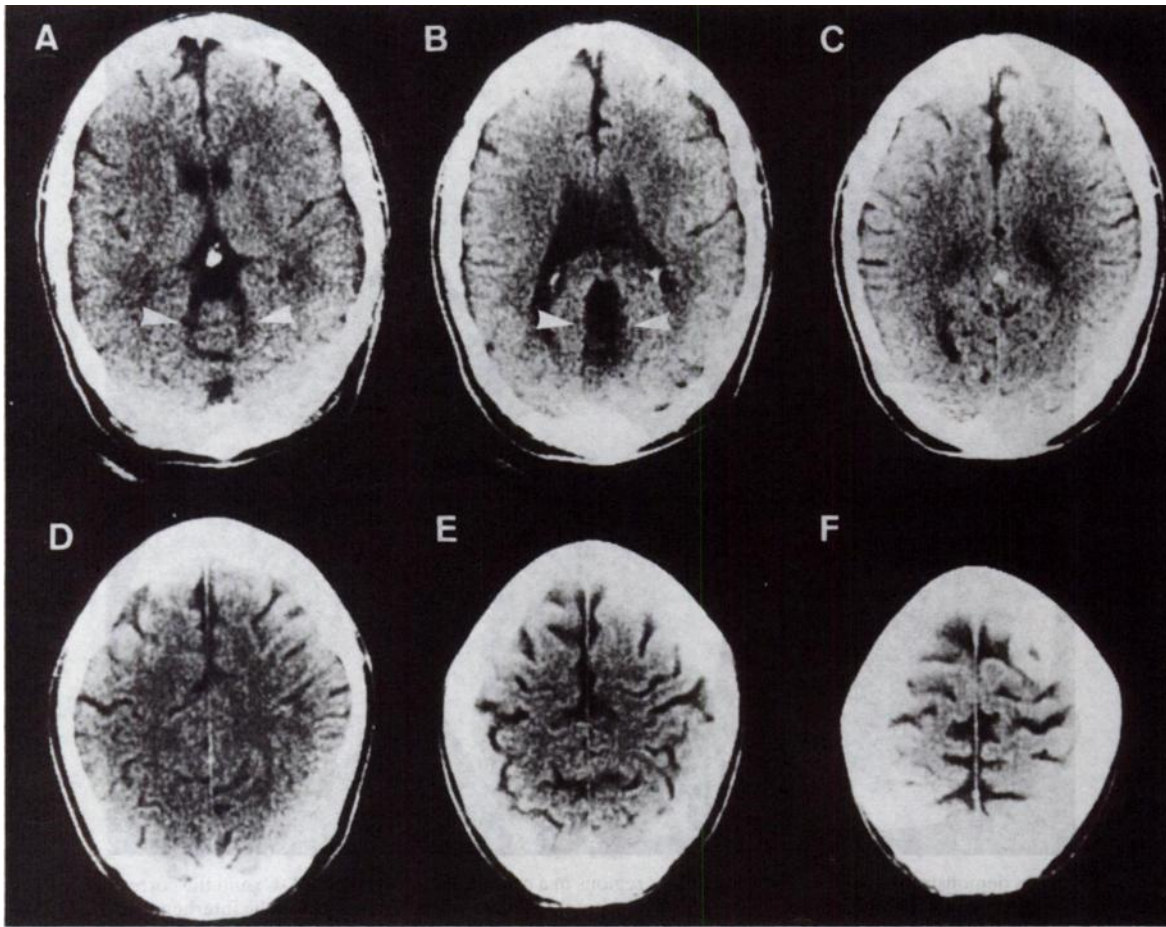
CT scans demonstrating vermian atrophy (A) and wide CSF space above vermis (B) in a 38 year old schizophrenic man. In (D-F) wide parietal sulci are demonstrated in the same patient.
